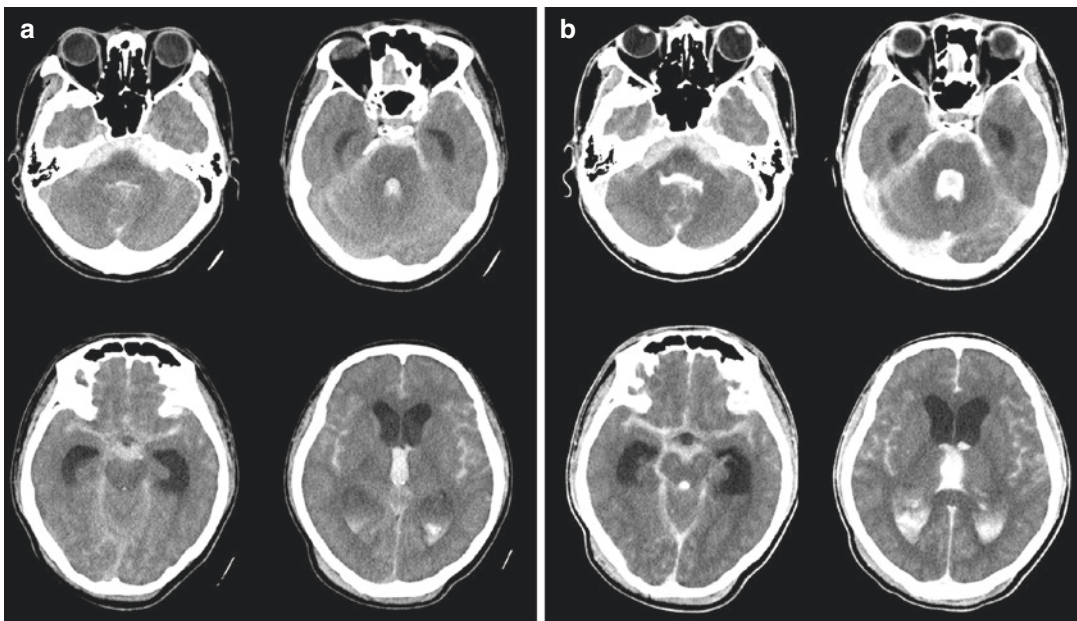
(a) Initial brain computed tomography (CT) scan of a 42-year-old male with stuporous mental status shows subarachnoid hemorrhage in the Sylvian, basal, prepontine, cerebellopontine, and cerebellomedullary cistern.
